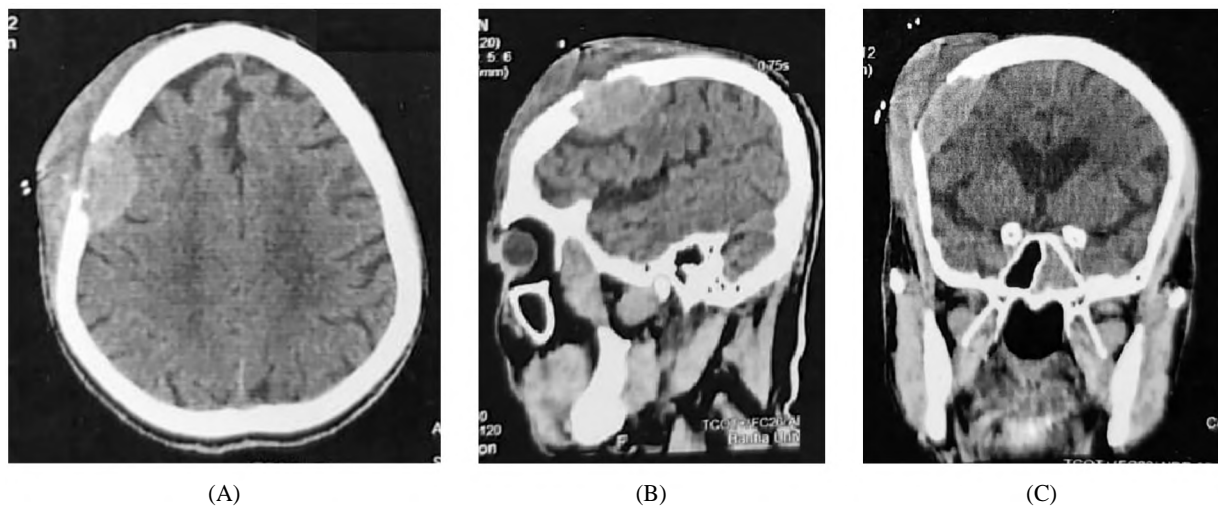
Preoperative CT scan of the brain without contrast (soft and bone window) (A: Axial view, soft tissue), (B: Sagittal view, soft tissue) (C: Coronal view, soft tissue) showing right frontal bony lesion with intracranial extra axial component and subgaleal soft tissue mass.
